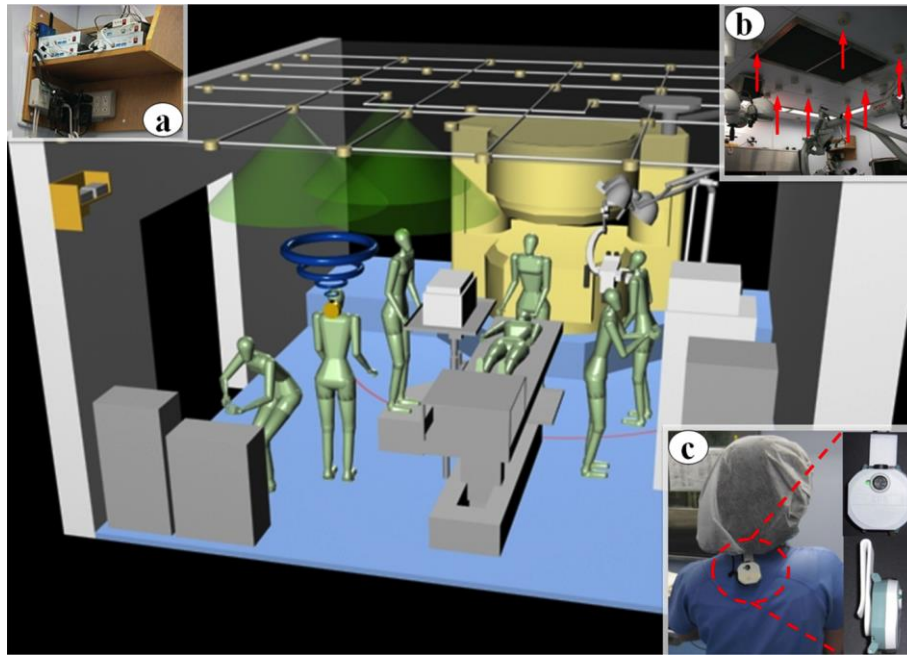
Ultrasonic 3D location aware system at Tokyo Women’s Medical University (Japan), consisting on control units (a), receivers (b) and transmitters (c); courtesy of Nara et al. (2009).
